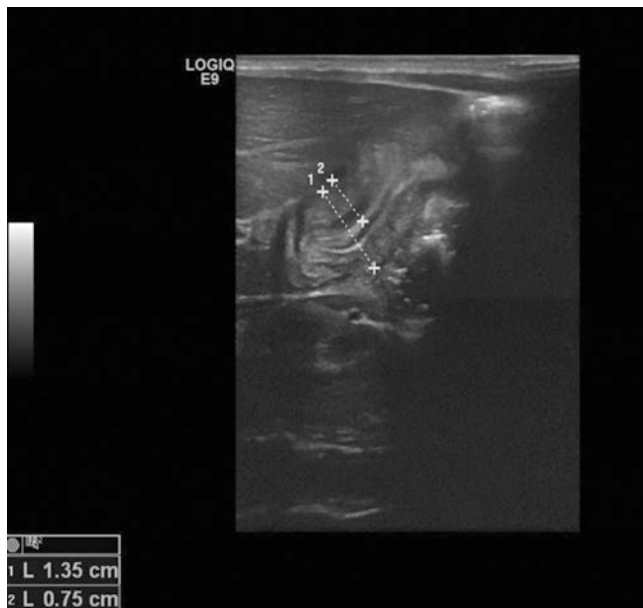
Pyloric stenosis ultrasound transverse view
